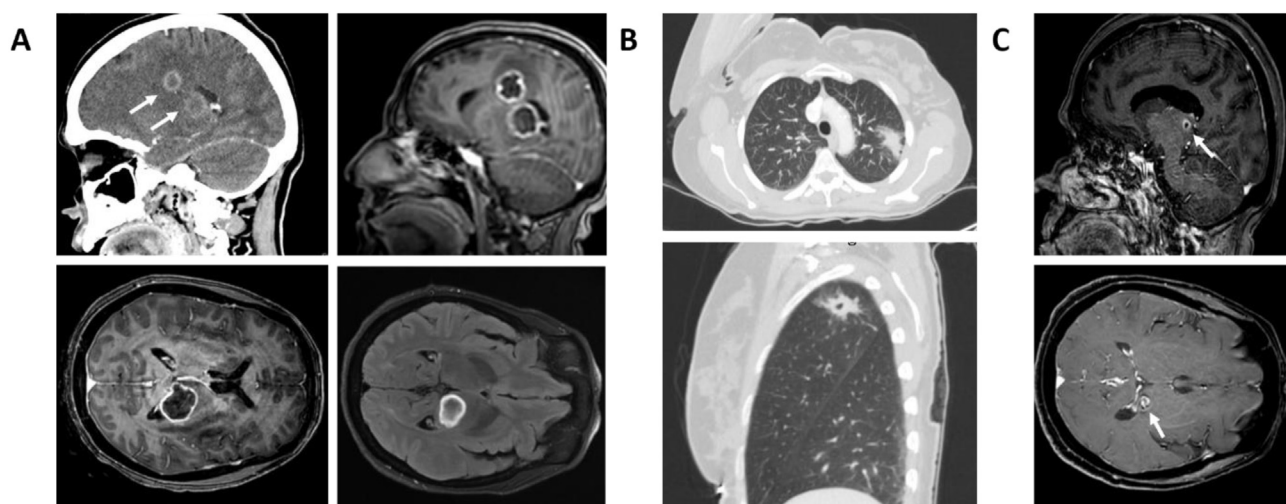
Imaging findings. (A) Head CT (left upper image) and MRI images obtained during the patient's first hospitalization showing two out of three brain abscesses (located in the left thalamus and left ventricle border). (B) Chest CT scan presenting a cavitory lesion with speculated borders in the left upper lobe. (C) MRI images obtained after ten weeks of antibiotic treatment, revealing a marked improvement in abscesses size. Abbreviations: CT, computer tomography; MRI, magnetic resonance imaging.
